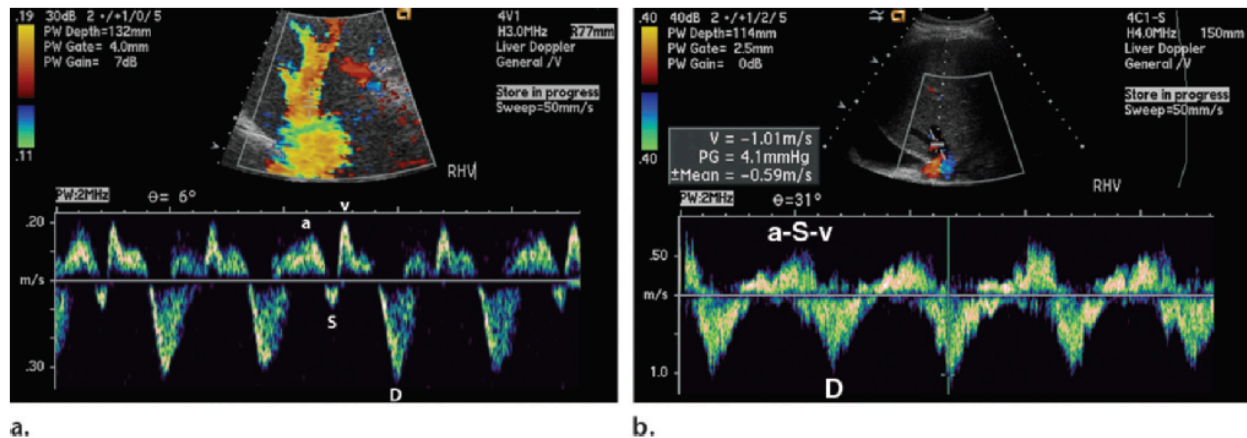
(a) Tricuspid regurgitation. Spectral Doppler image clearly depicts increased pulsatility (ie, wide variation between peaks and troughs). Careful observation shows a pattern that is specific for tricuspid regurgitation. The *v* wave is very tall, and the *S* wave is not as deep as the *D* wave. The latter finding may also be referred to as the “decreased *S* wave” and is specific for tricuspid regurgitation. When tricuspid regurgitation becomes severe, the *S* wave will no longer dip below the baseline, and there will be one large retrograde *a-S-v* complex, or “reversed *S* wave”; when this occurs, the *D* wave is the only manifestation of antegrade flow. (b) Reversed *S* wave. Spectral Doppler image shows a pulsatile waveform with a reversed *S* wave.
